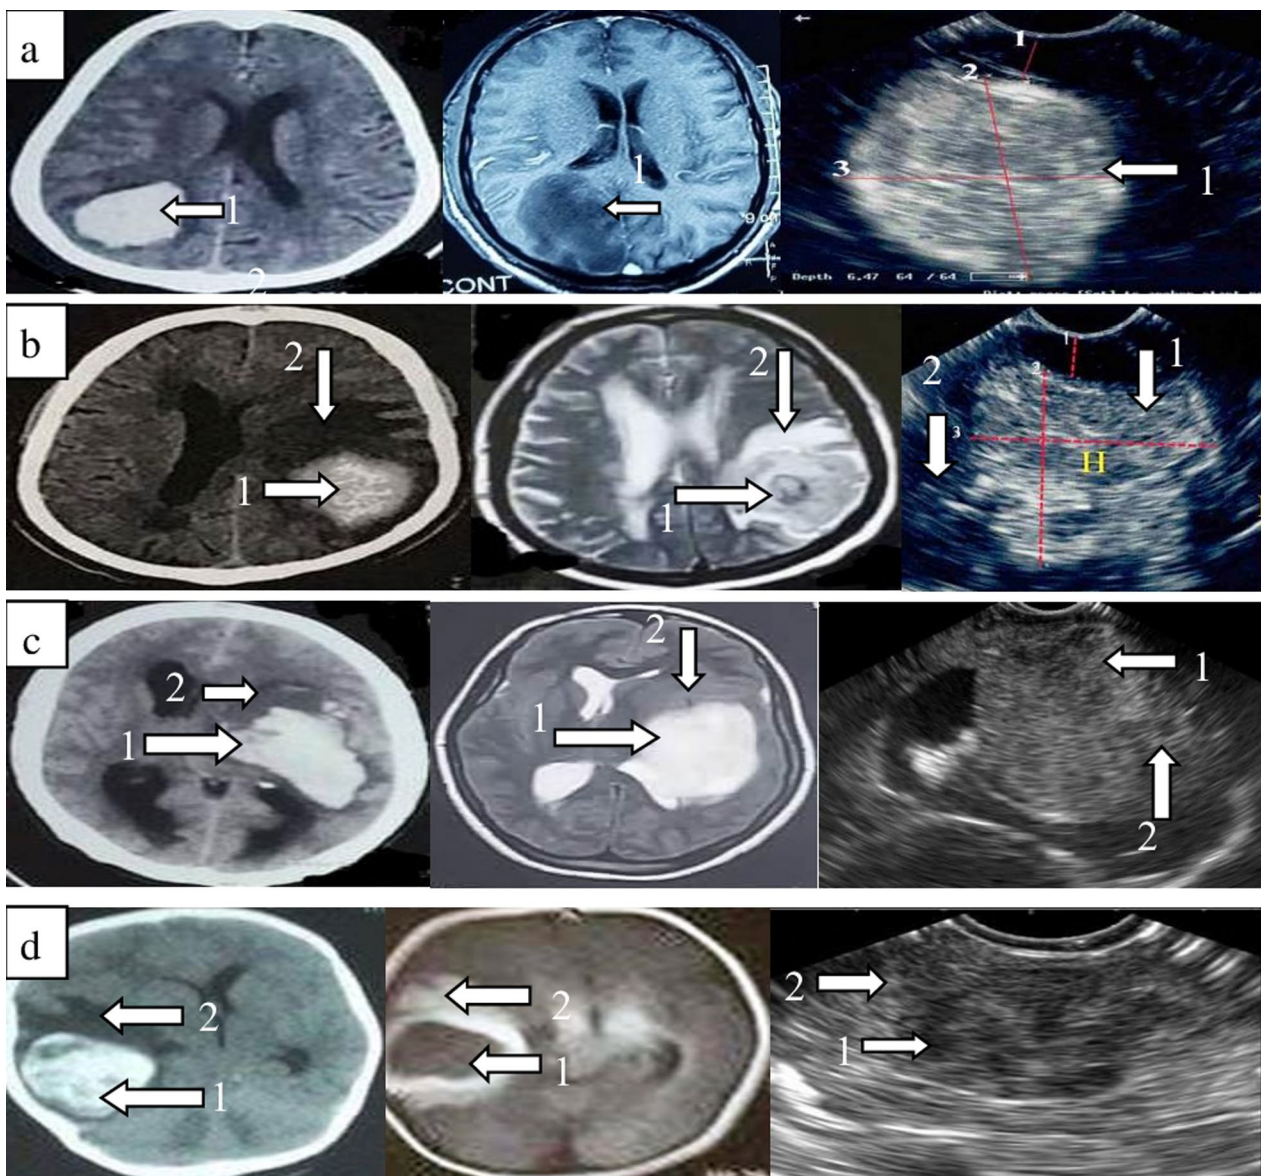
Imaging of intracerebral hematomas by CT, MRI, and IOUS. Arrows 1 refer to the hematoma and arrows 2 refer to brain edema. Case a: Acute intracerebral hematoma; homogenous hyper-dense in CT on day 1, homogenous hypo-intense in MRI T1 on day 1 and heterogeneous mostly hyper-echogenic in IOUS on day 2. Case b: Early sub-acute intracerebral hematoma; hyper-dense mostly homogenous in CT on day 5, heterogeneous hypo-intense in MRI T1 with contrast on day 6 and heterogeneous mostly hyper-echogenic in IOUS on day 7. Case c: Intracerebral hematoma; hyper-dense mostly homogenous in CT on day 5, homogenous hyper-intense in MRI on day 15 (late sub-acute) and homogeneous iso-echogenic in IOUS on day 15. Case d: Intracerebral hematoma; heterogeneous mixed densities in CT on day 10, homogenous hypo-intense in MRI on day 60 and heterogeneous hypo-echogenic in IOUS on day 60
